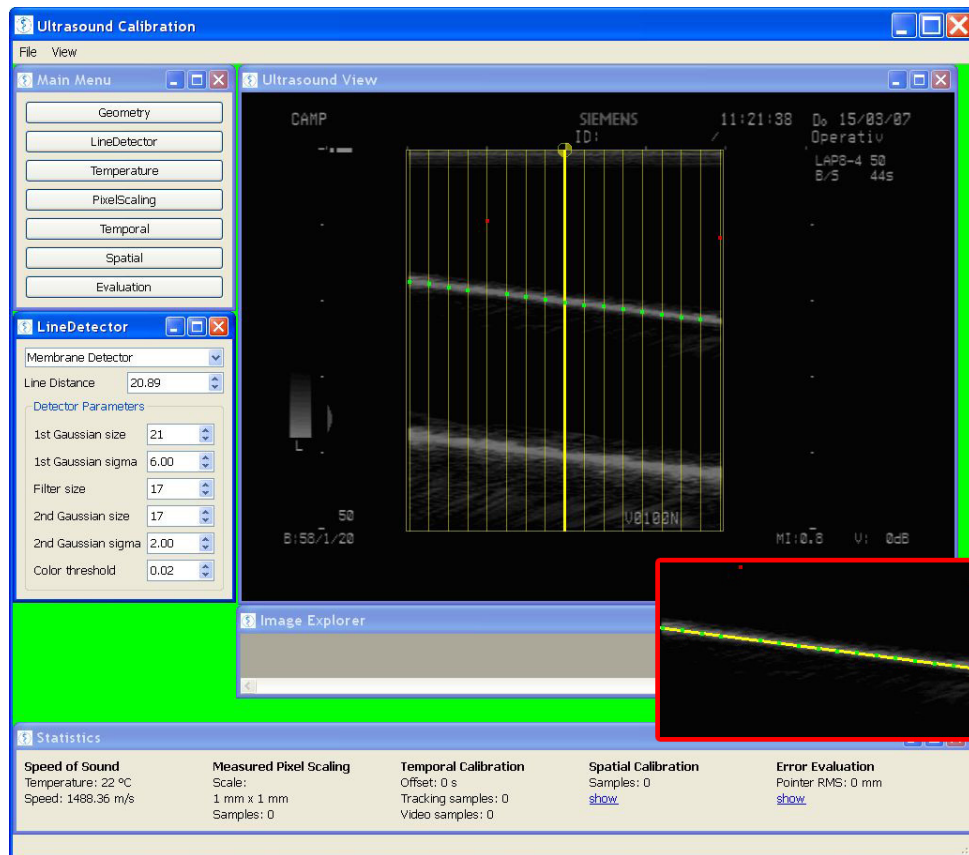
User interface developed for ultrasound calibration based on CAMPAR. It shows a B-scan image of the nylon membrane generated by the laparoscopic transducer. On the yellow vertical scan lines feature points are detected, which RANSAC either accepts (green points) or rejects (red points). The red framed inlet shows the line, which is finally fitted to all feature points.
